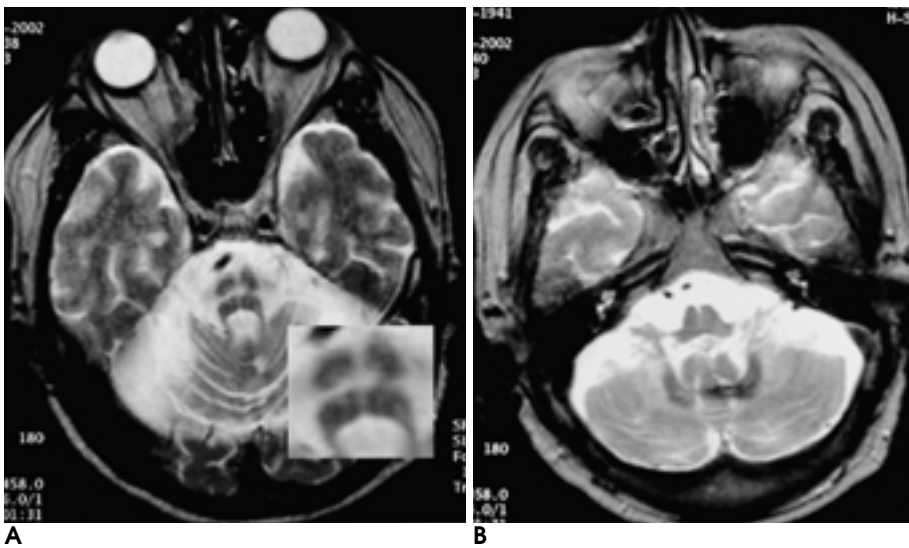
A. Cruciform signal hyperintensities within the pons and atrophy of pons are demonstrated on the axial T2-weighted MRI of 61-year-old patient (vase 4) with a 7-year history of cerebellar hemorrhage. B. In this patient, axial T2-weighted image shows hypointense hemosiderin rim in cerebellar vermis and paravermian structure.
